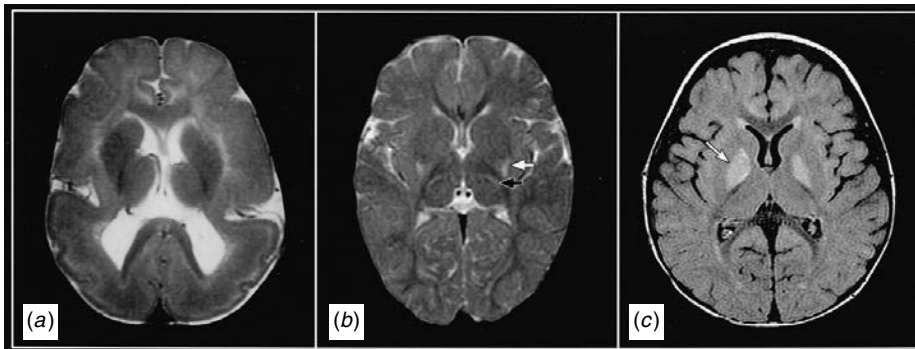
MR images from three children presenting with severe CP. (a) Lissencephaly in Miller–Dieker syndrome; (b) perinatal hypoxic–ischemic encephalopathy (from Fig. 39.3), and (c) methymalonic acidemia with globus pallidus hyperintensities (white arrows).
